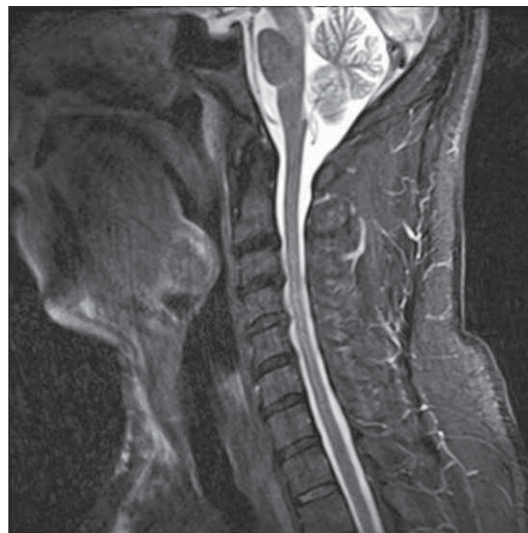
This sagittal T2 STIR MRI scan shows sharply delineated lesion at the base of tongue with higher signal intensity compared to surrounding musculature.
